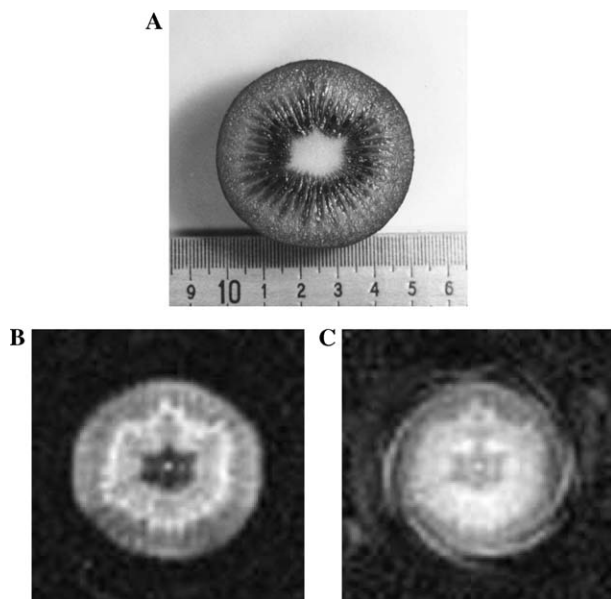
Photograph (A) and RUFIS MRI images (B and C; matrix size:  $45 \times 45$ ) of a kiwi fruit. For (B), eliminative averaging was used to remove the spin-lattice relaxation effect while (C) was obtained by regular (accumulative) averaging.
